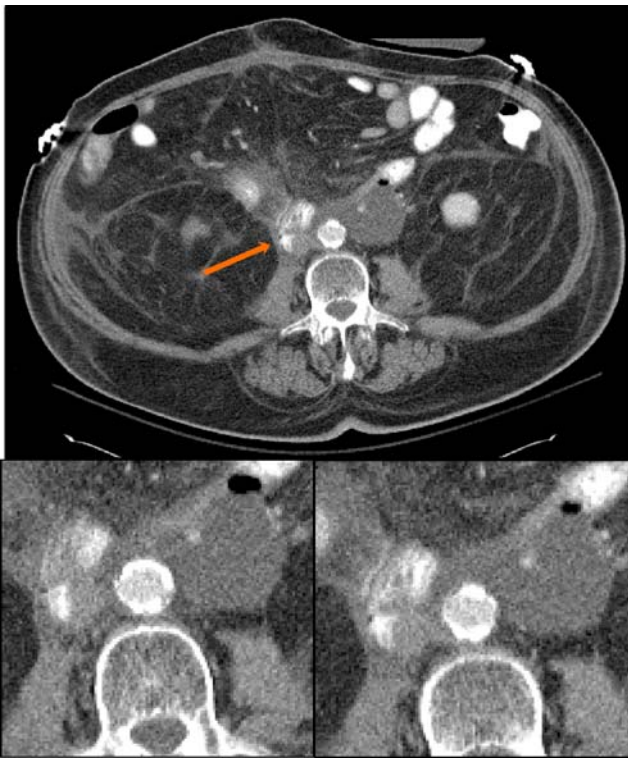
Enhanced CT chest abdomen and pelvis reveals mildly enlarged mediastinal lymph nodes, which have increased in size since previous exam. In the abdomen and pelvis, there is little change since 8-24-05 exam. Small amount of free fluid around the liver and in the right lower quadrant has developed. Otherwise the exam is unchanged. Left para-aortic fluid collection is stable.
